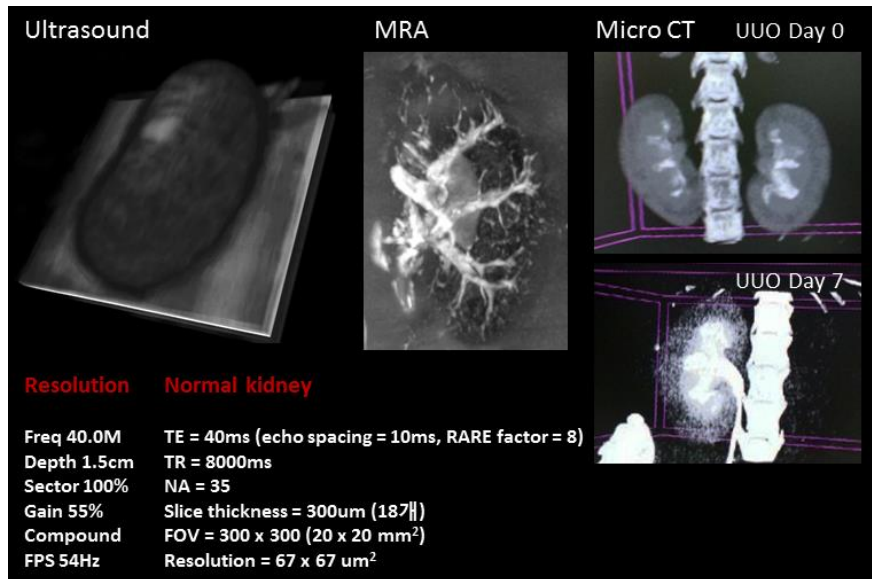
Comparative study of imaging modality. Ultrasound, MRA, CT images from left, respectively.
